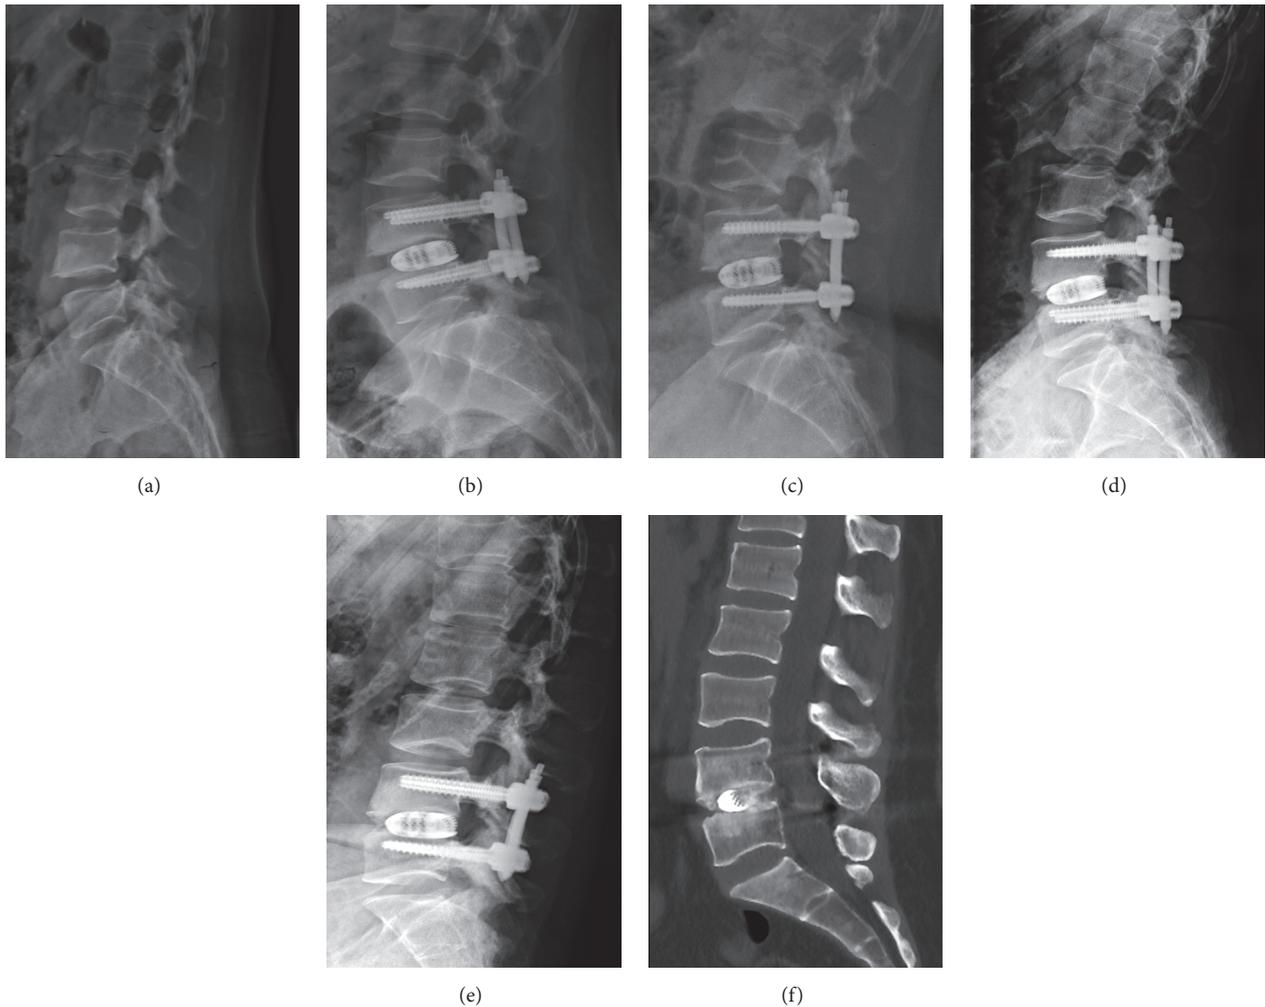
(a) Preoperative lateral radiograph showing isthmus spondylolisthesis. (b) and (c) Lateral radiograph at 1 and 12 months postoperative. (d) and (e) Extension and flexion lateral X-rays at two-years follow-up. (f) Sagittal CT image obtained 2 years postoperatively showing interbody fusion.
